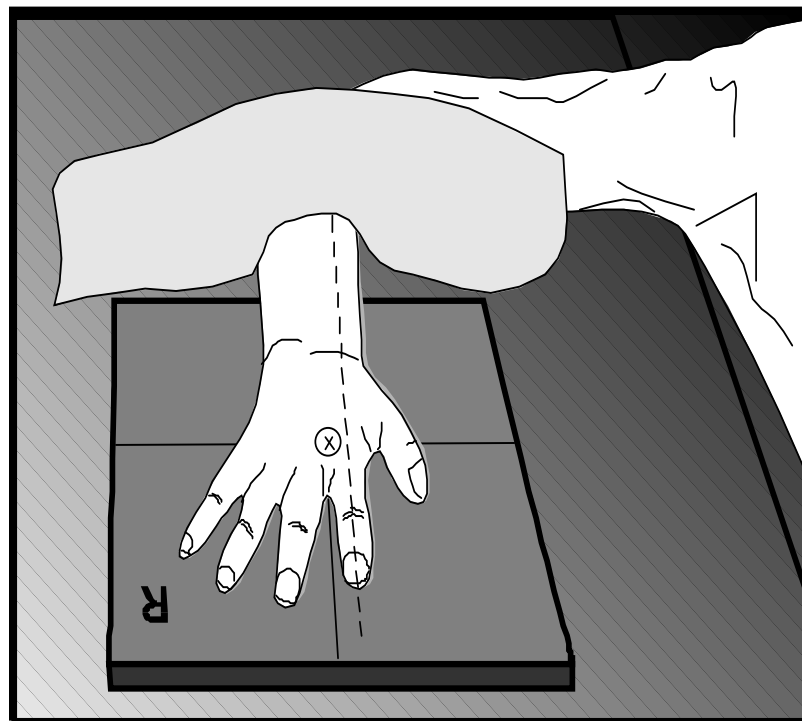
Proper Positioning of the Hand Unilateral: The hand is centered on the film with the palm and forearm pressed firmly against the cassette, the index finger aligned with the radius along the long axis of the cassette, and the fingers spread slightly. The x-ray beam should be centered between the 2nd and 3rd knuckles (⊗). A sandbag across the forearm helps stabilize the arm. Unilateral hand exposed on One Film: In the case of both hands
